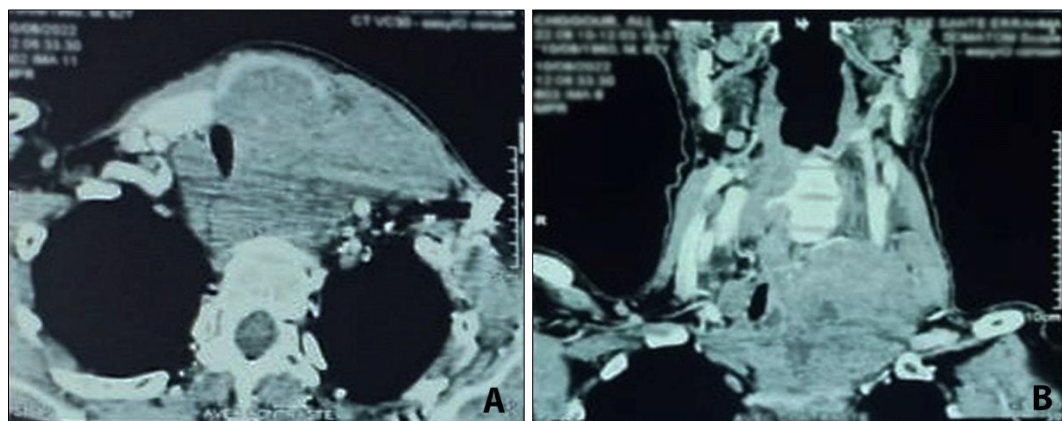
CT scan images demonstrating a voluminous and compressive goiter in a patient with thyroid disease, A: axial cuts, B: frontal reconstructions
